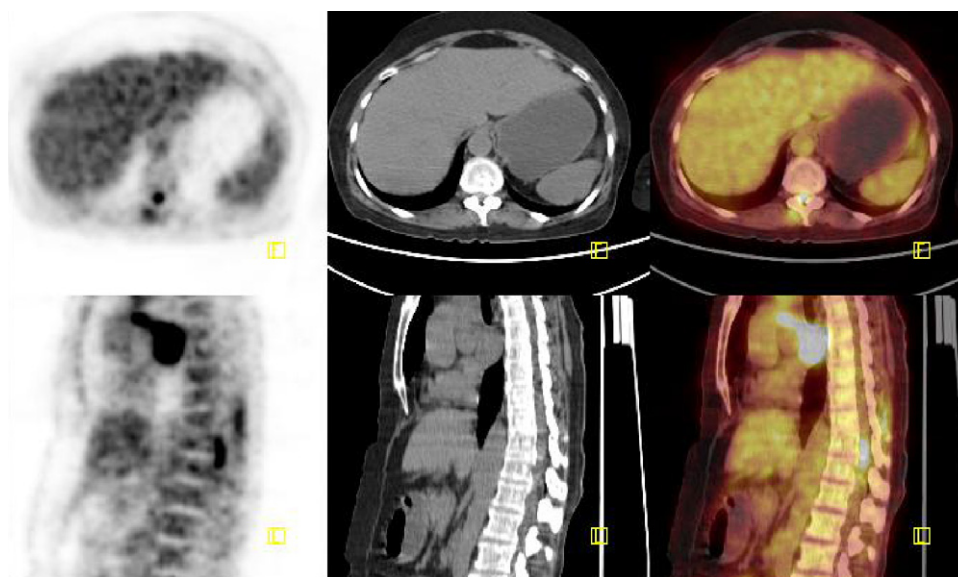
A 50-year-old woman with a history of shortness of breath, chest pain, back pain and hemoptysis diagnosed as lung cancer. The patient was done PET/CT for initial imaging. PET/CT showed an increased FDG uptake in the spine at the level of 11th thoracic vertebrae (SUVmax: 6.9). This focal lesion was an intramedullary metastasis.
